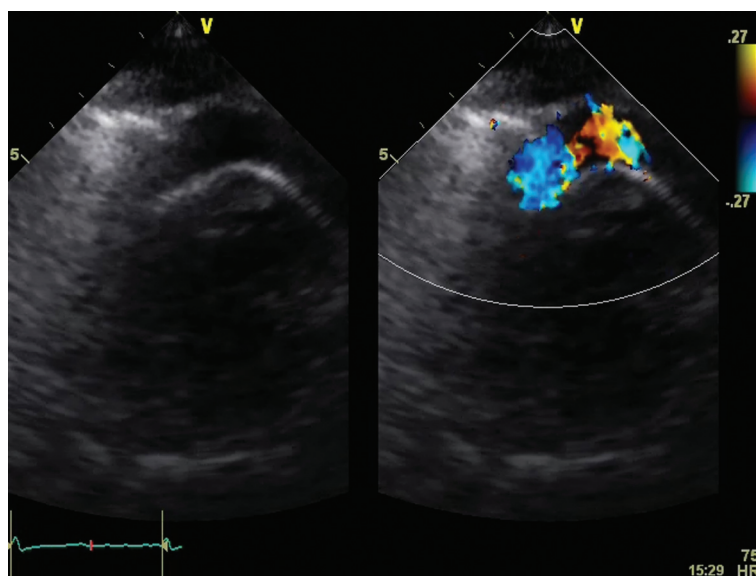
2-D and Color Doppler transthoracic echocardiographic examination, right parasternal view (second intercostal space). The outflow cannula with flow is visible.
